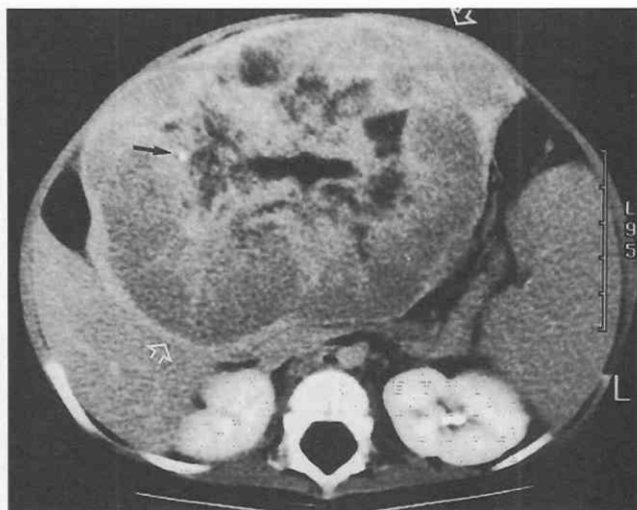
Hepatoblastoma. CT of a large unifocal hepatoblastoma shows a focus of calcification (*arrow*) in the heterogeneously low-attenuation mass (*open arrows*).
